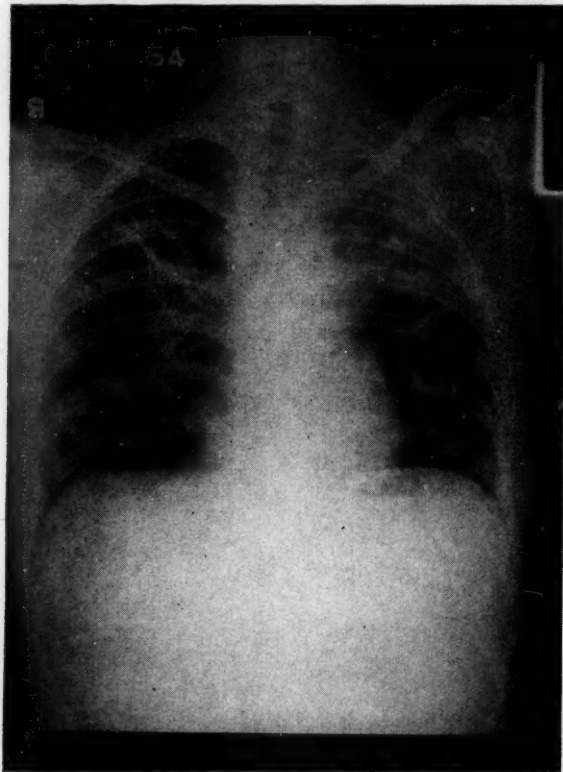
Chest x-ray, showing moderate clearing after one month of corticosteroid therapy.
